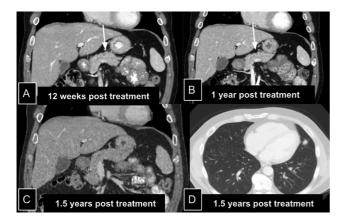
Coronal view of the contrast-enhanced CT of the abdomen was performed at 12 weeks (A), 1 year (B), and 1.5 years post-RAI treatment (C), which shows a continued decrease in size and enhancement of the pancreatic lesion at 6 weeks and 1 year (arrows) with non-visualization of the lesion at 1.5 years post-treatment representing resolution. (D) CT chest in lung window shows persistent pulmonary nodules.
